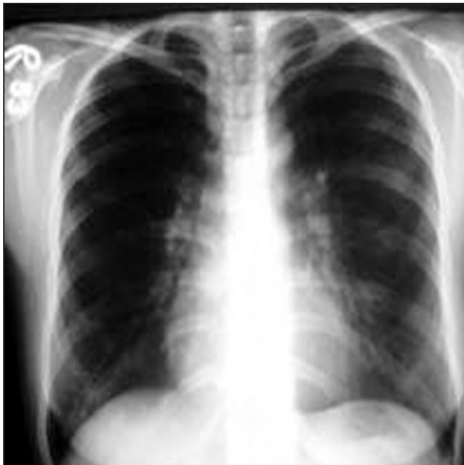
Chest X-ray after treatment.
